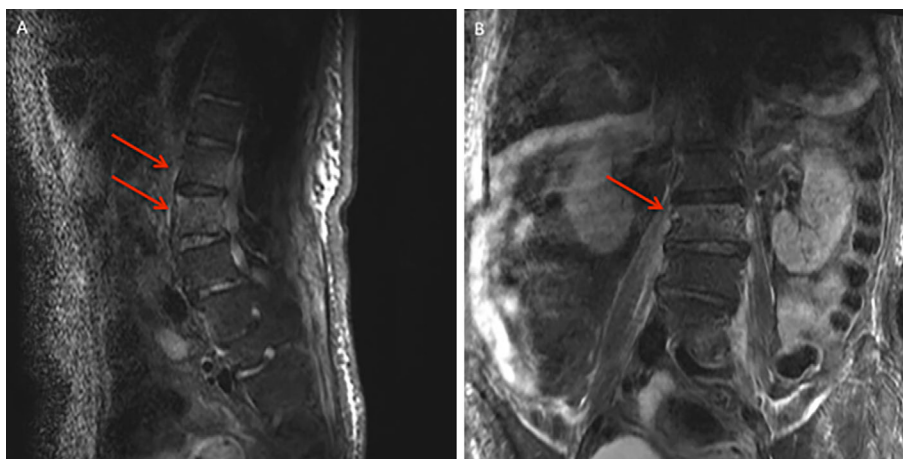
A STIR sequence in the MRI image showing a high signal at L1 and L2: (A) Sagittal view. (B) Coronal view. STIR: short TI inversion recovery
